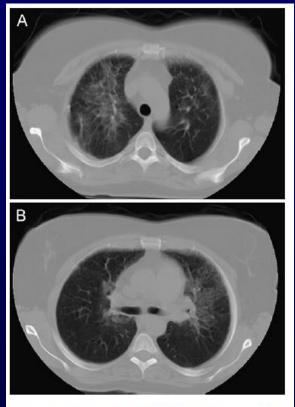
Axial CT images demonstrating patchy, bilateral 'ground glass' pulmonary infiltrates in (A) the right middle lobe and (B) the left lingula
